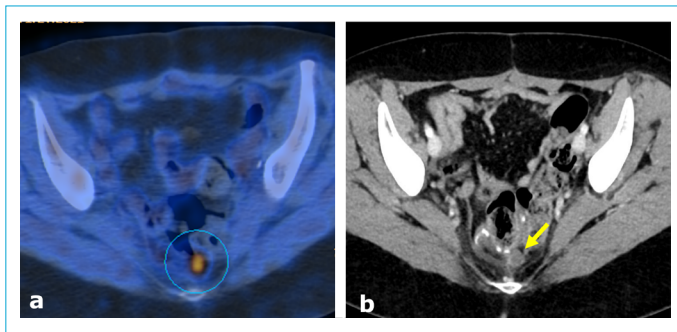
False-positive case. Patient radically operated for G3 serous carcinoma of the ovaries, stage IIIc, CA 125 at diagnosis 1142 U/mL, adjuvant chemotherapy performed. Routine follow-up PET-CT (a) performed in complete well-being, with normal and stable CA 125 value (11 U/mL at the time of examination, 10 U/mL 3 months before), showed a focal area of increased glucose uptake adjacent to the posterior rectal wall (circle), suspicious for tumor recurrence. The patient did not undergo any further treatment. Contrast-enhanced CT (b) performed 6 months later (CA 125 10 U/mL) showed lesion stability (arrow); given its para-anastomotic location and hypoattenuating core, the lesion has been considered an inflammatory fluid collection.
